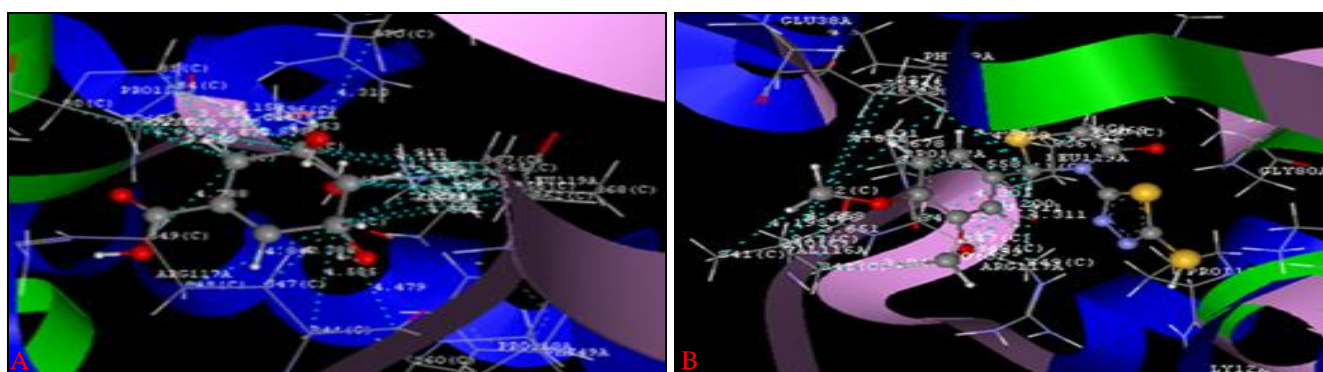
(A) AND 3(B): HYDROPHOBIC BONDING INTERACTIONS WITH LEU119, PRO11, GLY80, GLY81, ARG117 IN THE DOCKED MOLECULE OF SHIKIMATE (3A) AND ARG117, LEU119 IN THE DOCKED MOLECULE OF 4J IN THE ACTIVE SITE OF SK (PDB CODE: 2IYQ) RESPECTIVELY. (SHOWN IN CYAN BLUE DOTTED LINES)
